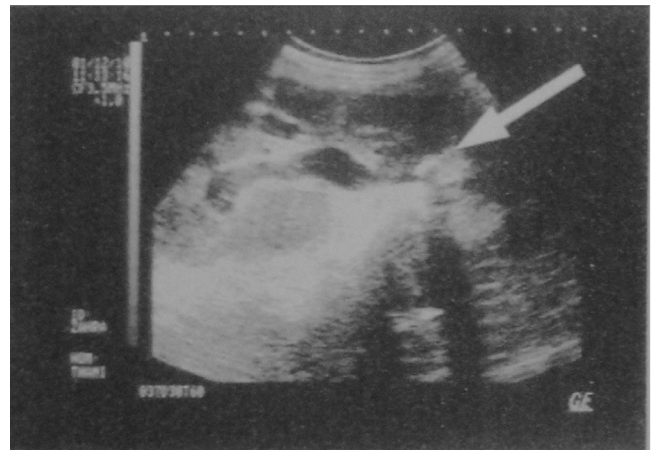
Renal ultrasound tomography showing a urinary stone.
